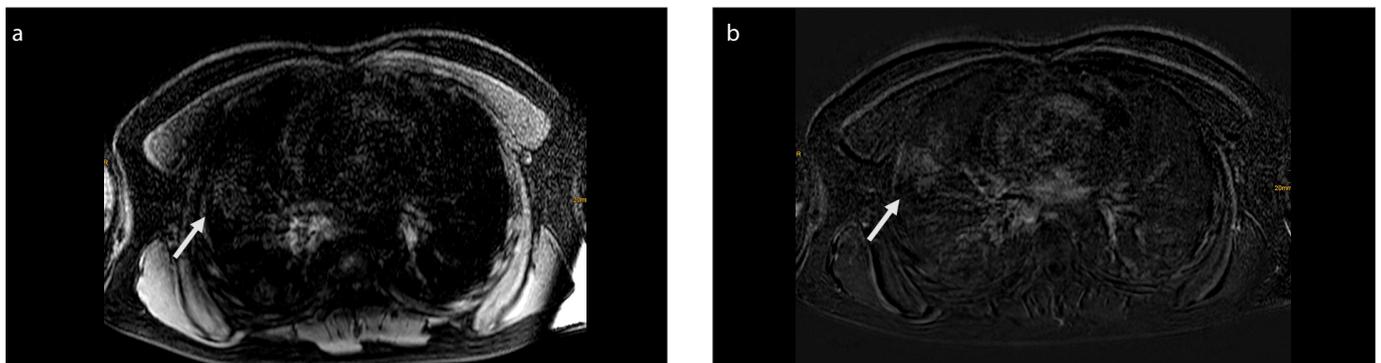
a, b. T1-weighted sequences pre-contrast (a) and 4 minutes after contrast injection (subtraction) (b) with bilateral, multiple, slightly enhancing lung consolidations (a, b, arrow).
